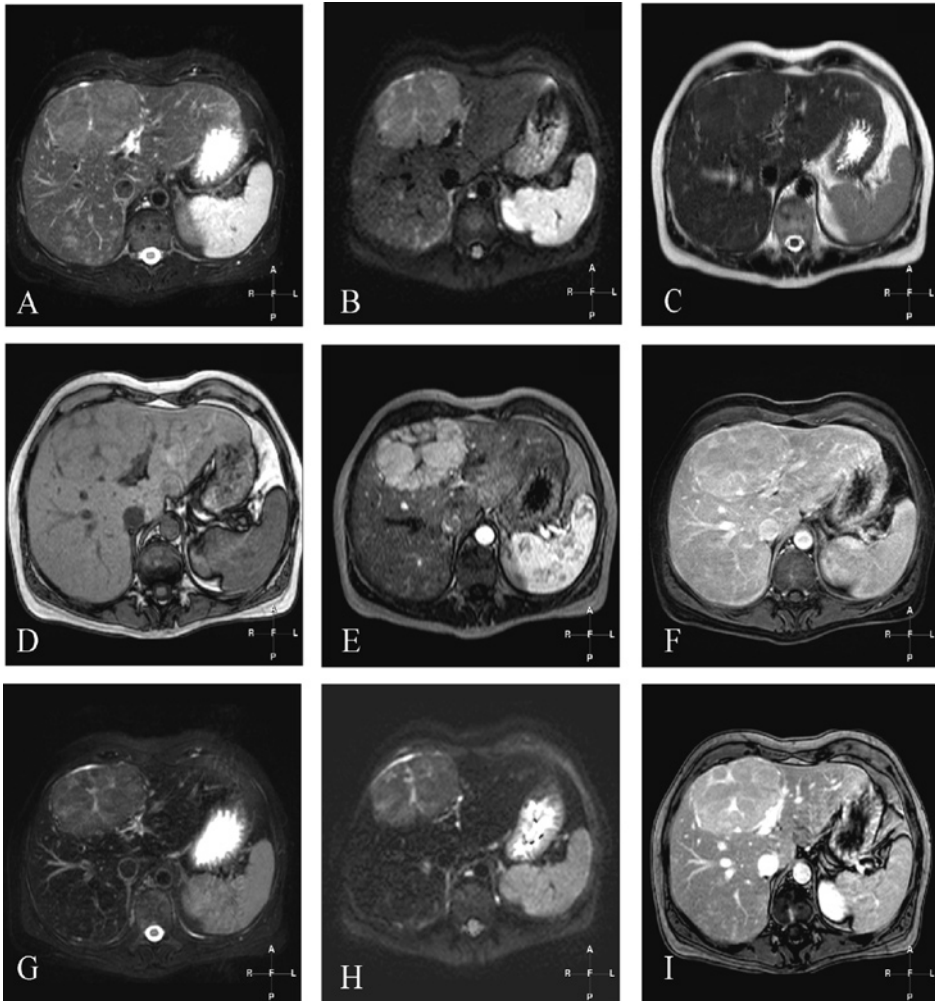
State-of-the-art MR imaging of classical FNH; signal intensity, enhancement patterns and uptake of SPIO. A. Fat-suppressed T2-weighted fast spin-echo (FSE): large, well circumscribed FNH in the left liver lobe, just slightly hyperintense to the liver, with a faint hyperintense septa. B. Black-blood T2-weighted echo planar imaging (BBEPI): hyperintense signal intensity, with hyperintensity of central scar and septa. C. Single-shot T2-weighted fast spin-echo (SSFSE): the lesion is isointense with the liver. D. Opposed-phase T1-weighted gradient echo (GRE): the lesion is isointense, with hypointense central scar, septa and pseudocapsule composed of compressed vessels. E. Arterial phase Gadolinium (Gd)-enhanced T1-weighted GRE: immediate, homogeneous enhancement with sparing of central scar and septa. F. Delayed phase Gd-enhanced 3D T1-weighted GRE: the signal intensity has faded to isointensity with the liver, with faint delayed enhancement of central scar, septa and pseudocapsule. G. Post-SPIO fat-suppressed T2-weighted fast spin-echo (FSE): the liver and spleen have dropped in signal intensity after SPIO. The lesion is hyperintense, with slightly improved conspicuity of central scar and septa. H. Post-SPIO diffusion T2-weighted black-blood echo planar imaging (BBEPI): better conspicuity of central scar and septa, with high signal intensity. I. Post-SPIO opposed-phase T1-weighted gradient echo (GRE): high signal of central scar and septa, especially when compared to delayed phase 3D dynamic Gd-enhanced imaging (F).
